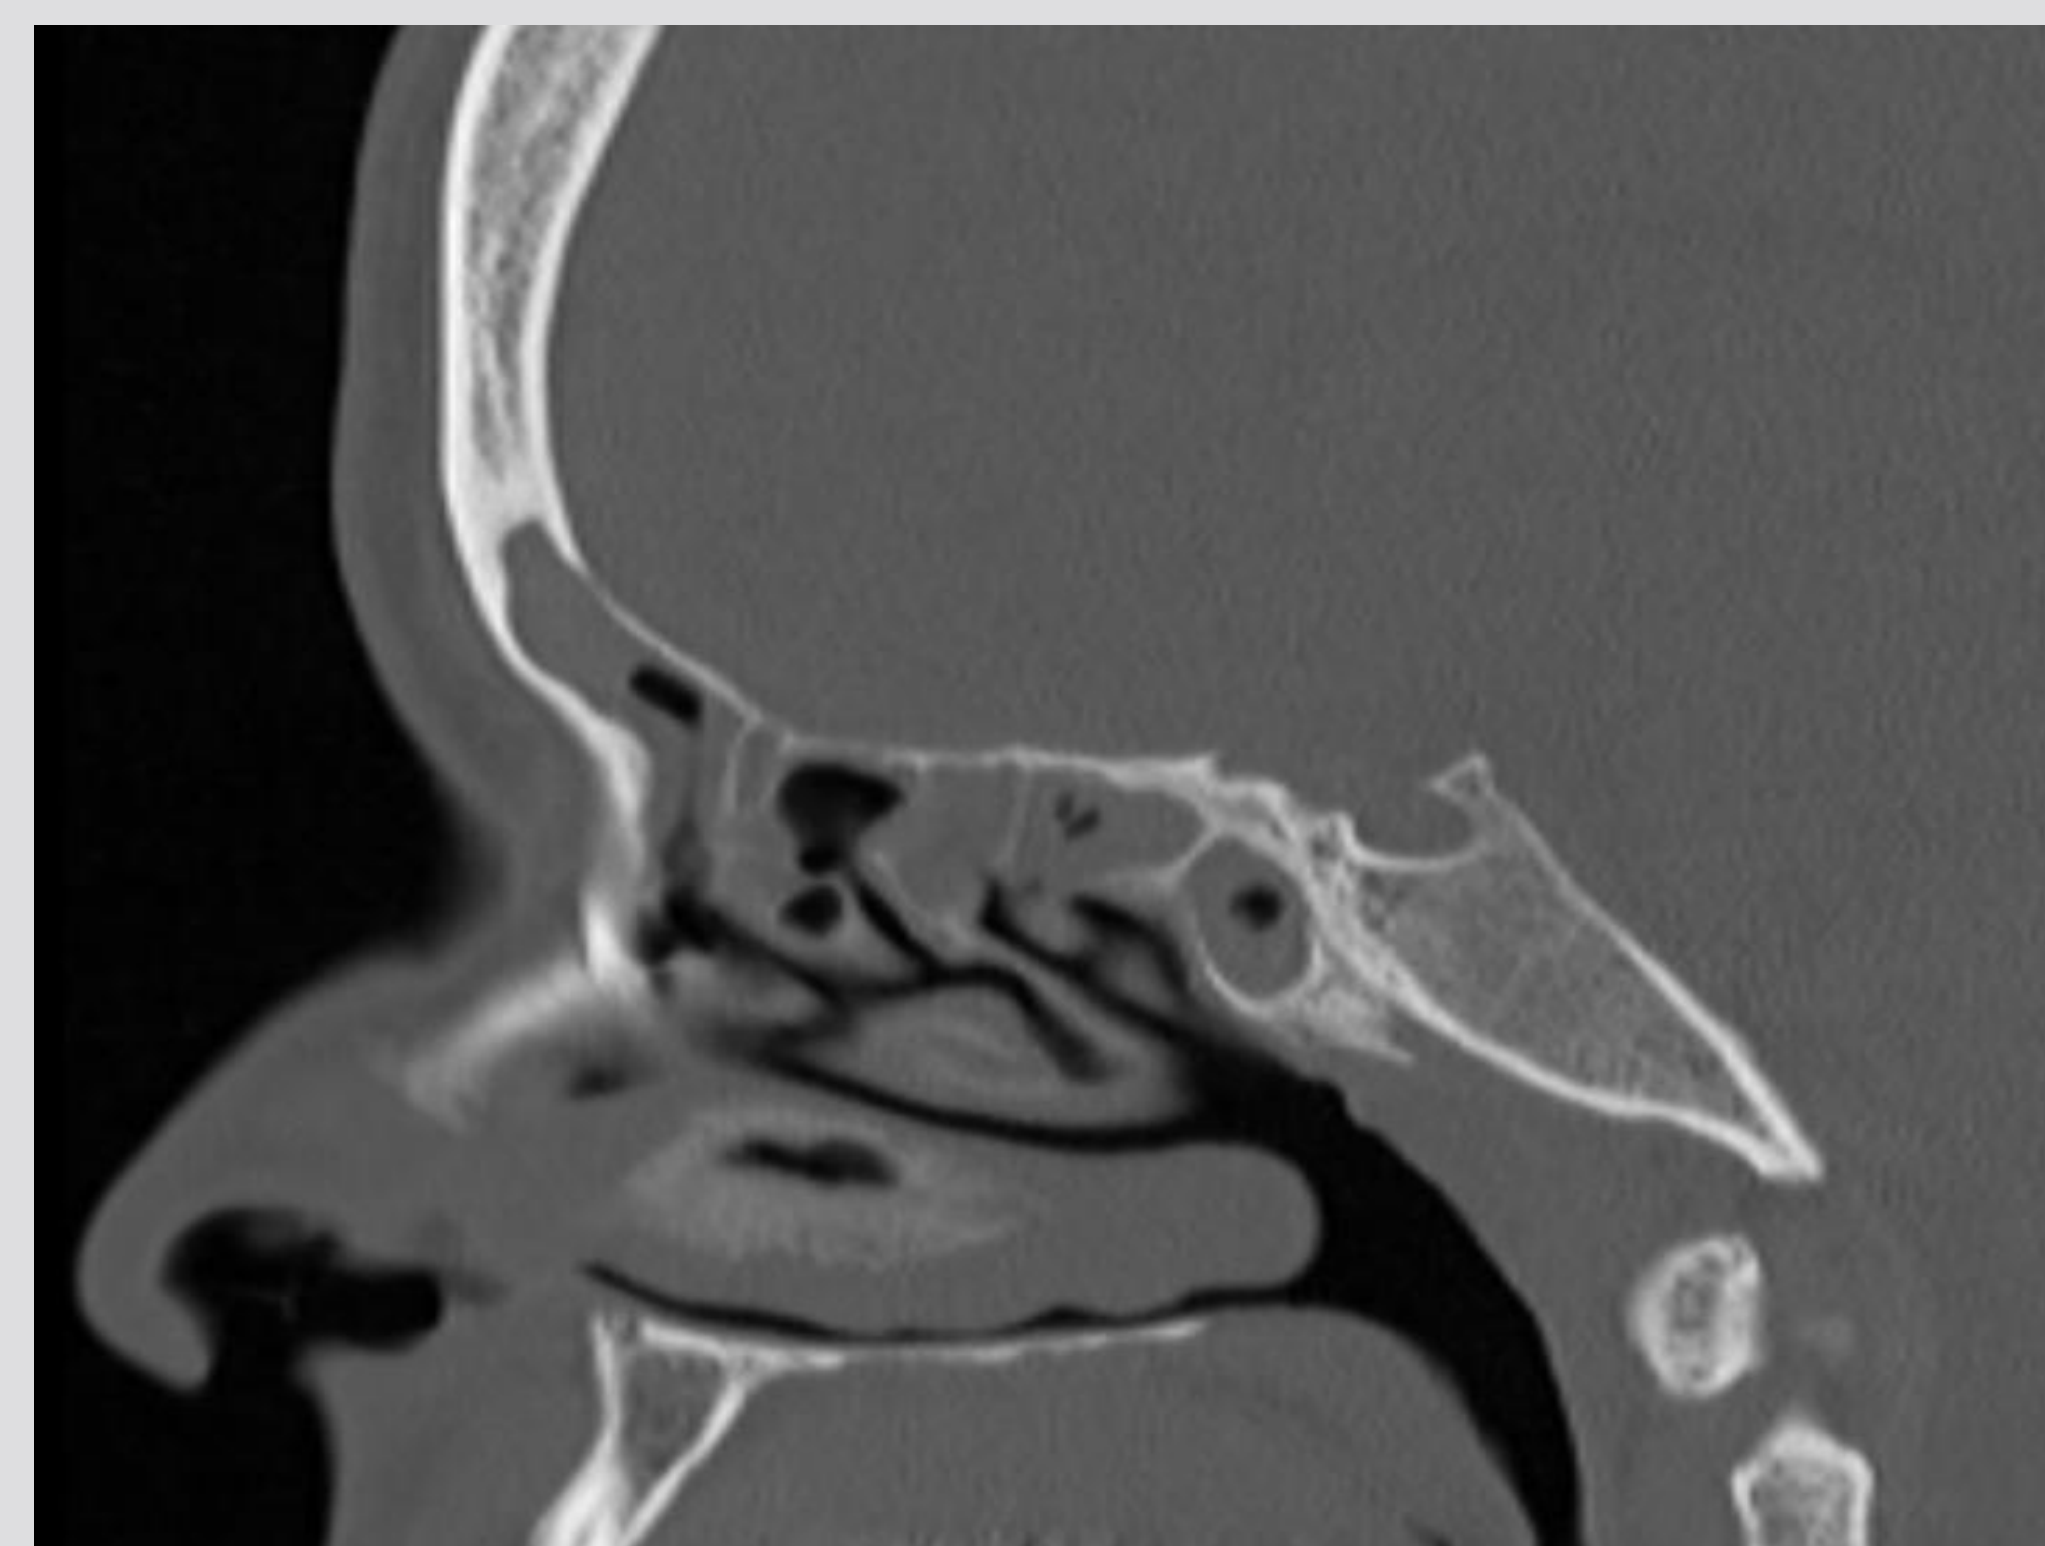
Sagittal CT scan of the sinuses in a patient with CF
